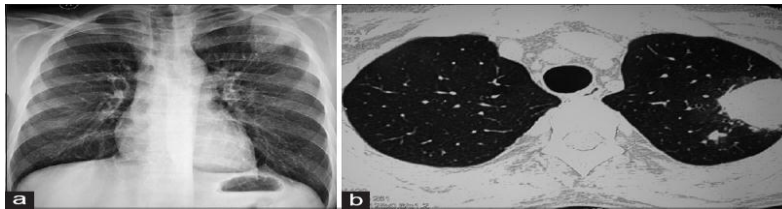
(a) a chest radiograph of a renal allograft recipient infected with *Nocardia* spp. showing left upper lobe mass lesion. (b) Corresponding computerized tomography revealing mass-like consolidation.^[26]
